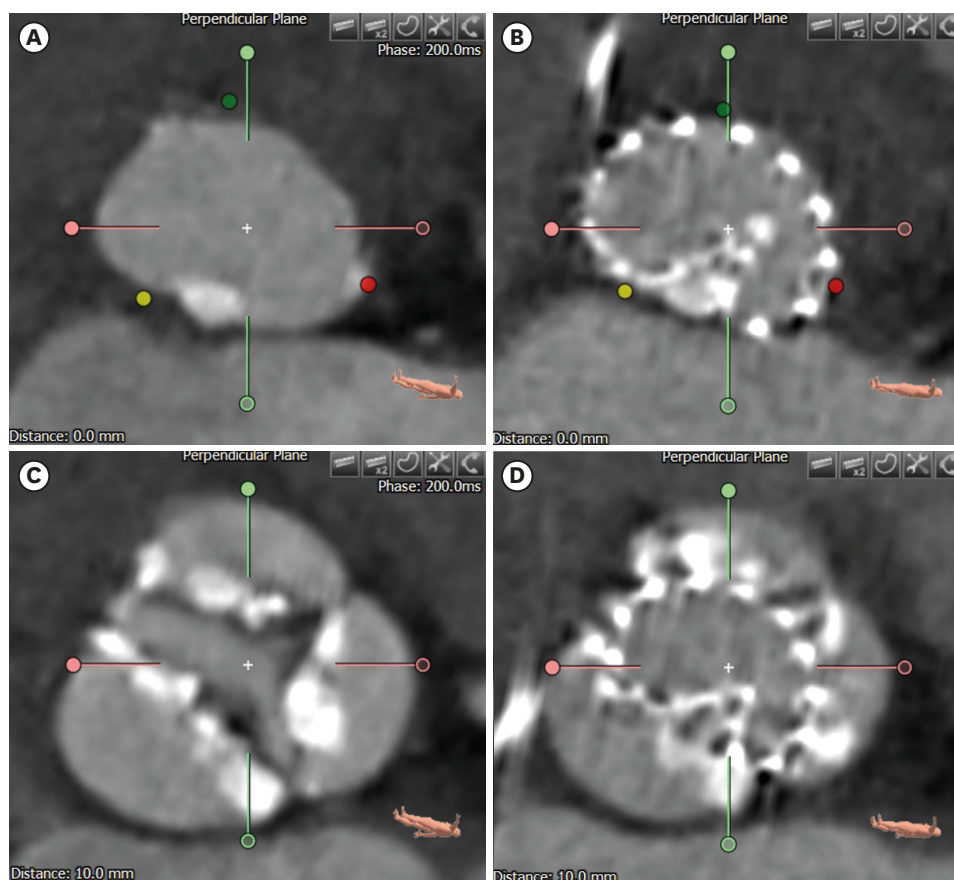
Computed tomography images between and after TAVR. Images at annulus level: (A) pre-TAVR and (B) post-TAVR and at Valsalva sinus level: (C) pre-TAVR and (D) post-TAVR. TAVR = transcatheter aortic valve replacement.
